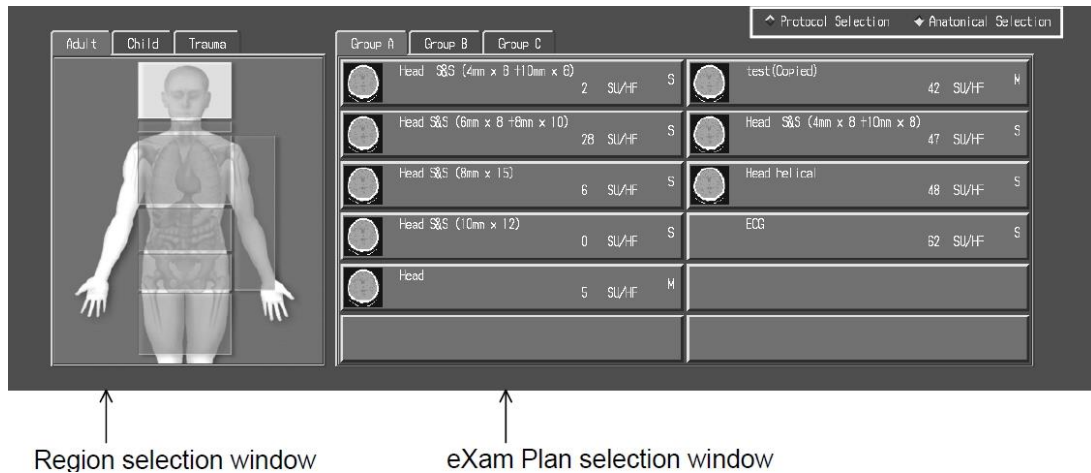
Protocol selection on Toshiba Aquilion © LB CT scanner.
